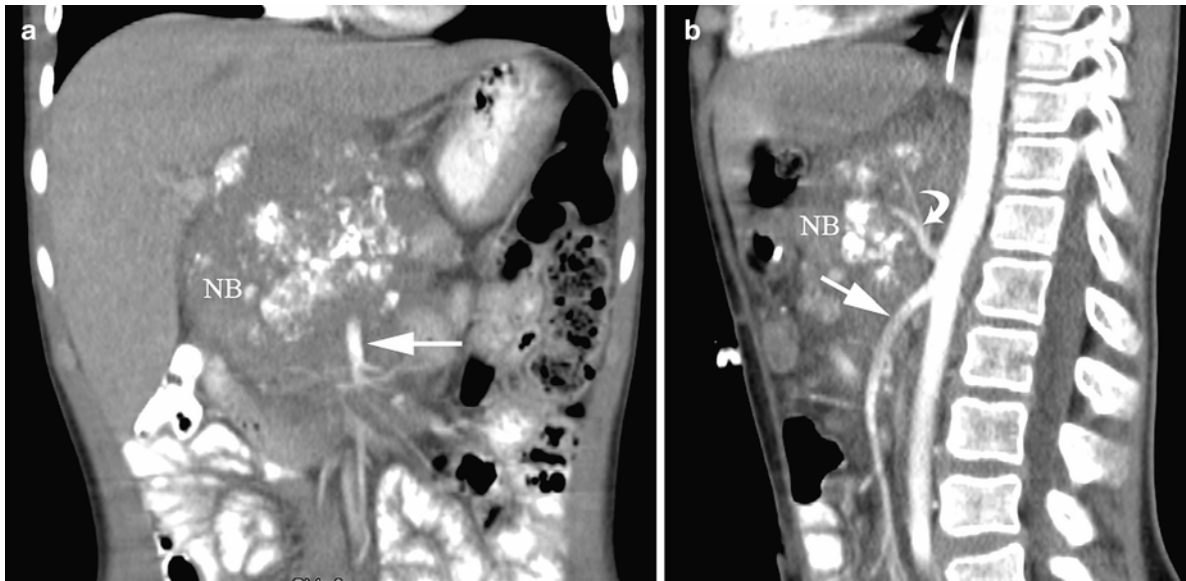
These (a) coronal and (b) sagittal reconstructed computed tomography images provide valuable information regarding the relationship of this neuroblastoma (NB) to the superior mesenteric (*straight*
